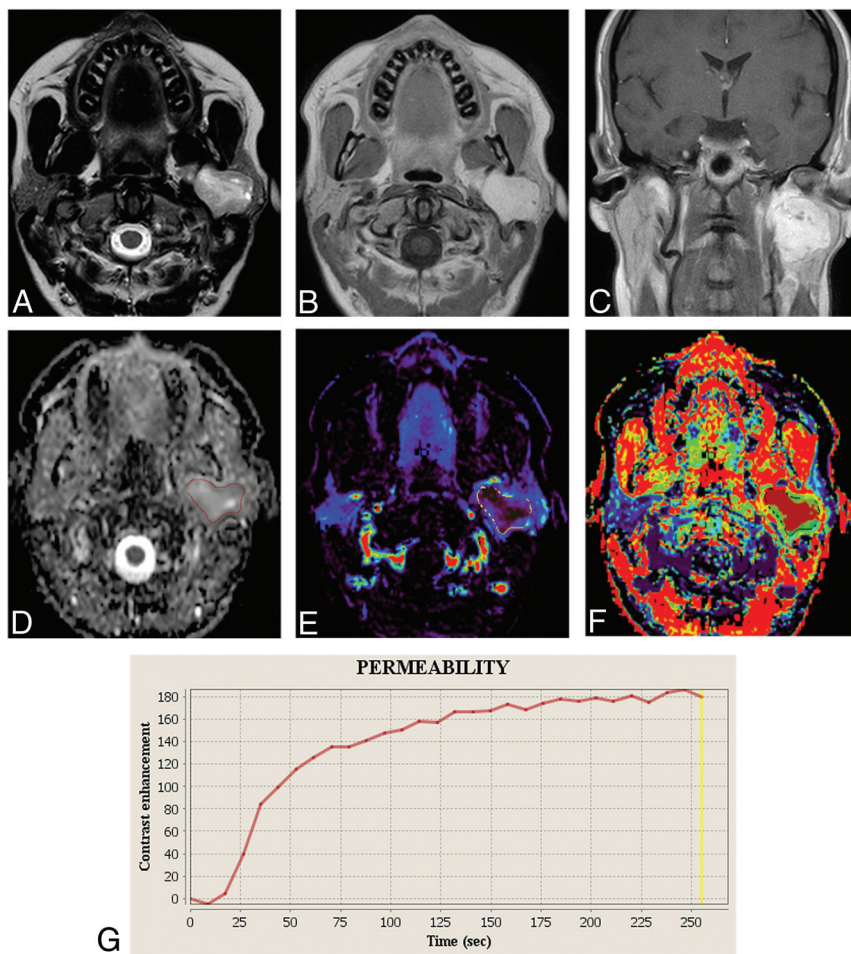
A 41-year-old woman with a schwannoma in the left parotid space. A, T2-weighted image shows a hyperintense mass in the left parotid gland. B and C, Contrast-enhanced T1-weighted image shows homogeneous enhancement. D, Mean ADC and normalized mean ADC are $1.15 \times 10^{-3} \text{ mm}^2/\text{s}$ and 1.48, respectively. E and F, Vp and TME are demonstrated. G, The TIC demonstrates a low peak enhancement with a long time-to-peak.
